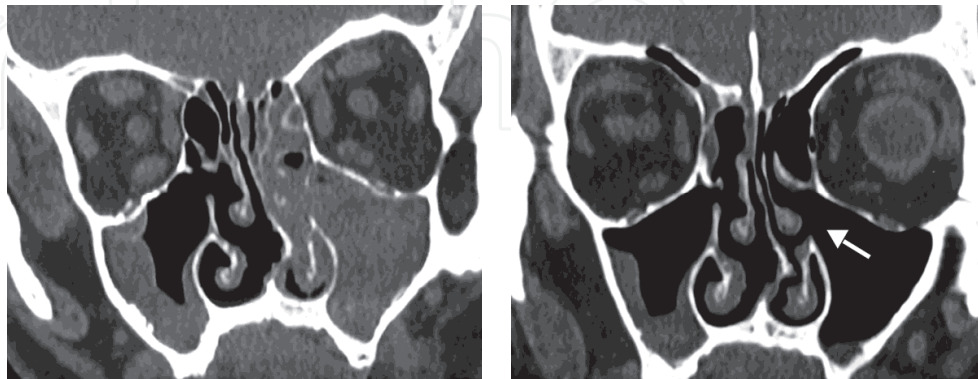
a. Coronal CT scan of odontogenic sinusitis demonstrating pronounced inflammation of left maxillary sinus and anterior ethmoidal cells. b. Six months postoperatively reduction in extent of sinus inflammation, as well as resection of the uncinete process (arrow) are clearly visible. Previously published in ref: Andric et al, 2010.
